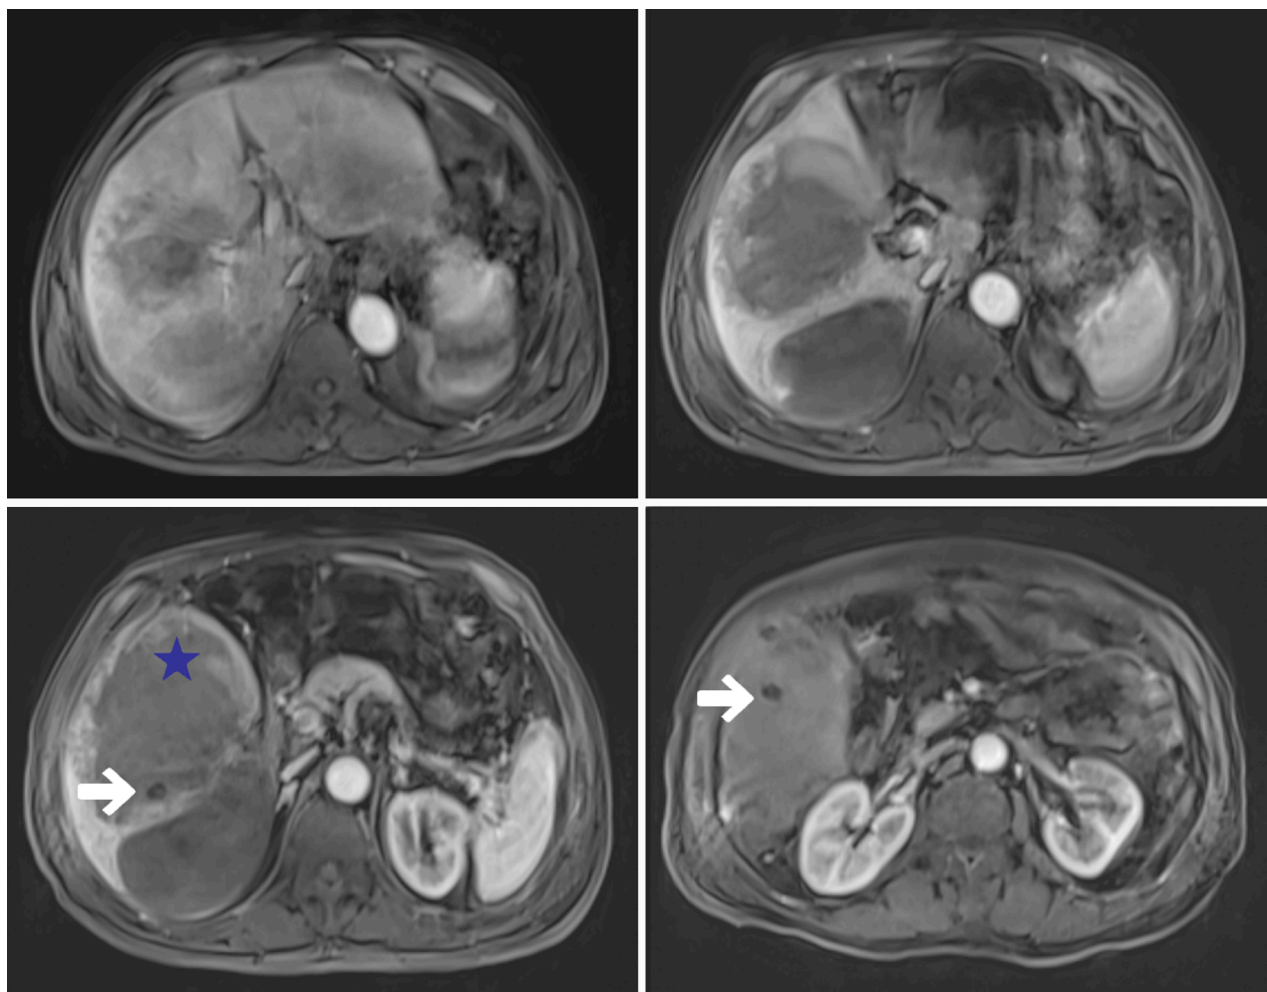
Magnetic resonance imaging of the abdomen showing a mass of mixed signal in the right lobe of the liver. White arrow: Several rounded long T1 signals in the mixed-signal mass; Blue star: The “hole sign”.
